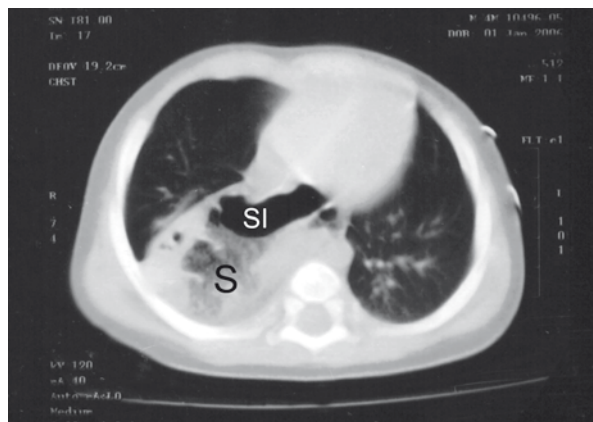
Thorax computed tomography scan. S - stomach; SI - was interpreted as the small intestine in the right posterior part of the thorax
